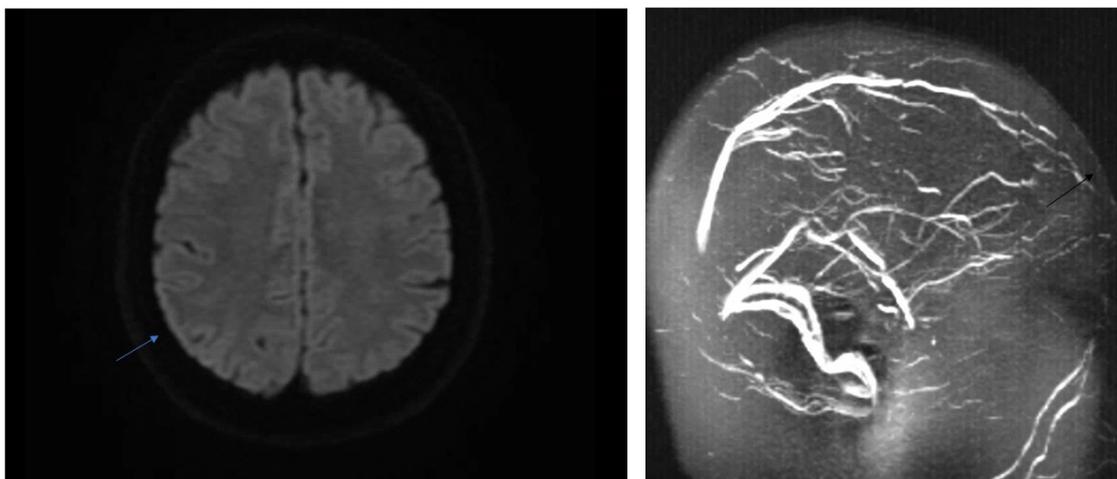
MRI brain revealed tiny focus of restricted diffusion left posterior parietal lobe on the Diffusion-weighted magnetic resonance imaging (DWI) series, which may represent a small area of acute or subacute ischemia; and anterior portion of superior sagittal sinus appears thinned and irregular, which may represent partial thrombosis
